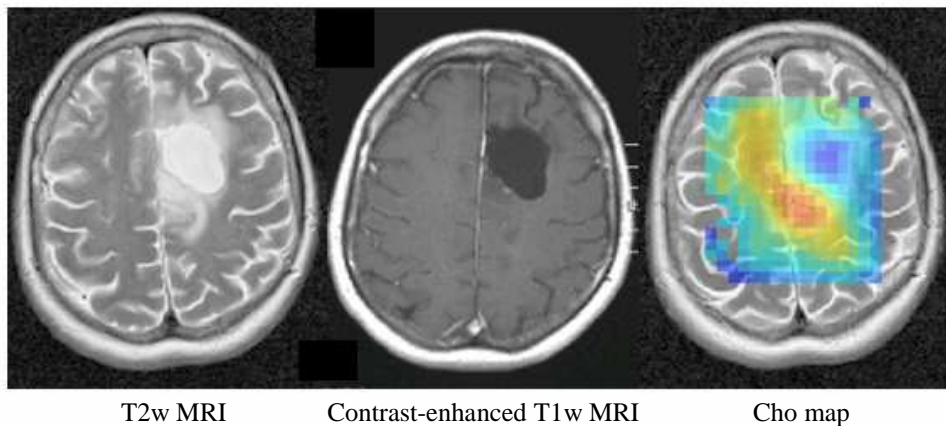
T2-weighted and contrast-enhanced T1-weighted MR image and the metabolic map in a patient with suspected tumour recurrence. The patient with oligoastrocytoma grade II was treated by subtotal tumour resection. T2w, T2-weighted image; T1w, T1-weighted image; Cho, choline-containing compounds.
